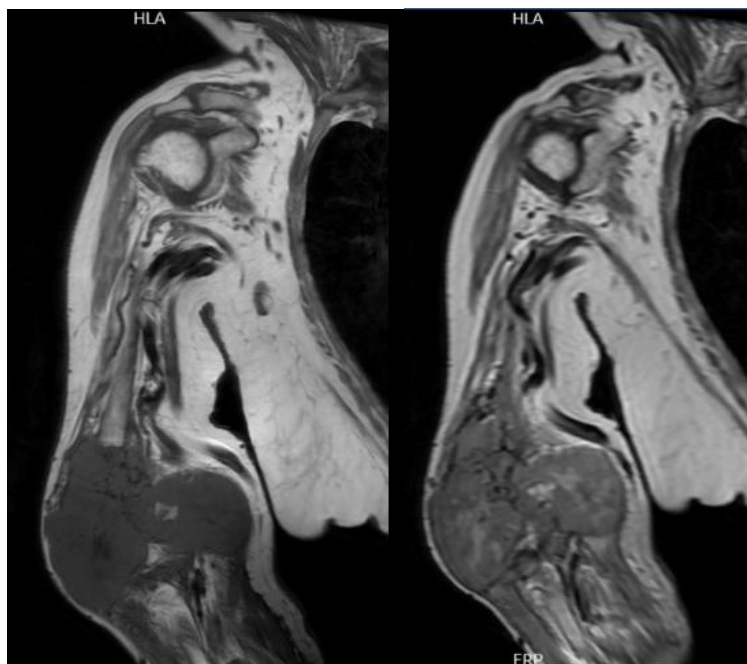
Magnetic resonance imaging (MRI) of the right humerus with contrast.
